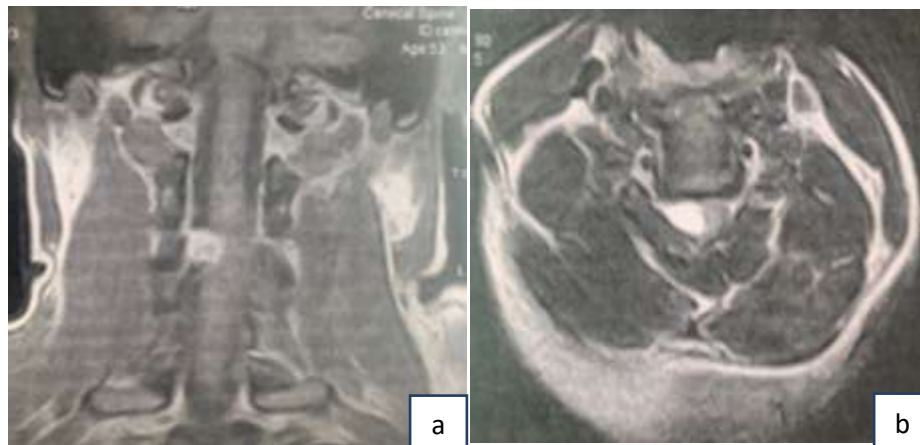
Preoperative Cervical MRI
